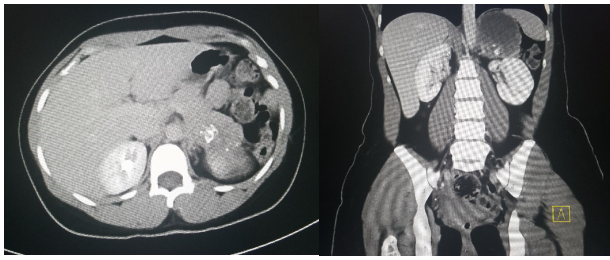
Axial and coronal views of CT scan images of left supra-renal mass
